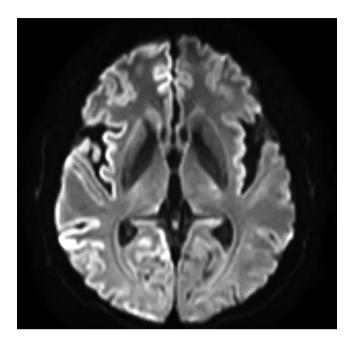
Diffusion-weighted MRI (DWI) shows marked cortical diffusion restriction with right hemispheric predominance, especially in the frontal and temporal lobes. Hyperintensities in the right caudate nucleus and lateral putamen suggest a "cortical ribboning" pattern typical of sporadic Creutzfeldt-Jakob disease.
